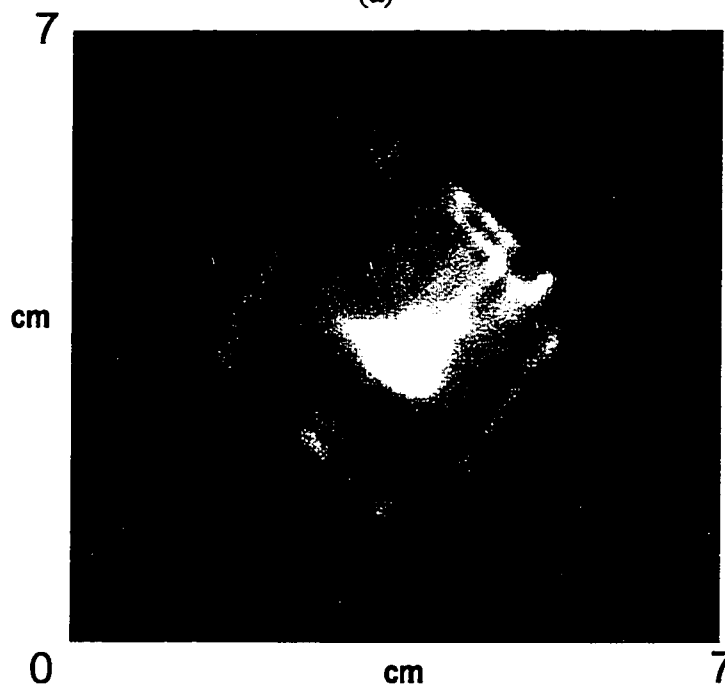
(a) A three-dimensional topographic view of the tactile map made of a portion of the right breast of a 47 year old Caucasian woman. (b) False color contour plot showing a scar from a previous biopsy (on the left) and a benign lump of normal breast tissue. The scar was estimated to be 5 cm by 2 cm using CBE, while the lump was estimated to be 5 cm by 5 cm, while in the tactile image the scar is 4.5 cm by 2 cm and the lump is 3 cm by 3 cm. The lump was 1.3 cm by 1.1 cm on the ultrasound images.
